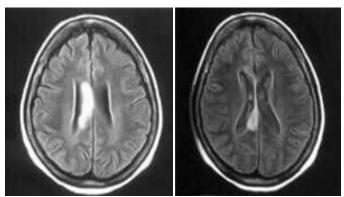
MRI brain T2 weighted image axial view showing corpus callosum infarct
